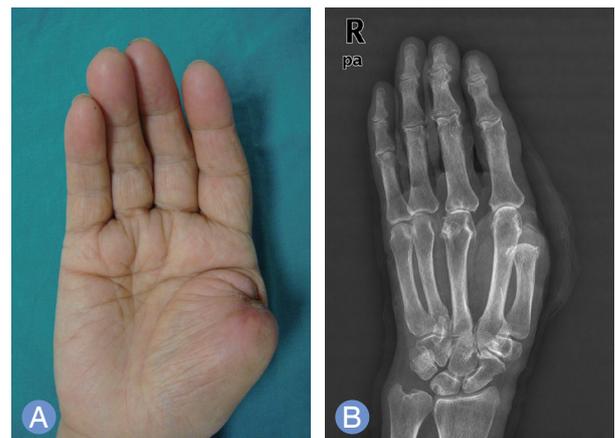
(A) Surgical amputation was performed at the metacarpophalangeal (MCP) joint level. (B) Postoperative X-ray, posteroanterior view showing the final result.
